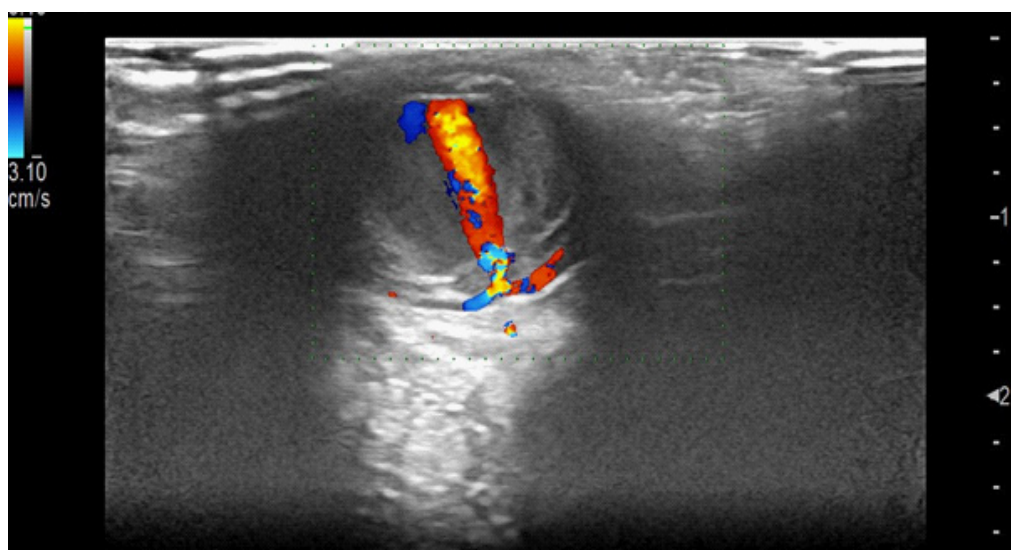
Pulsed colour doppler imaging of a left occipital pseudoaneurysm with swirling flow and slow internal circulation, communicating with the occipital artery via a fine perforation.
